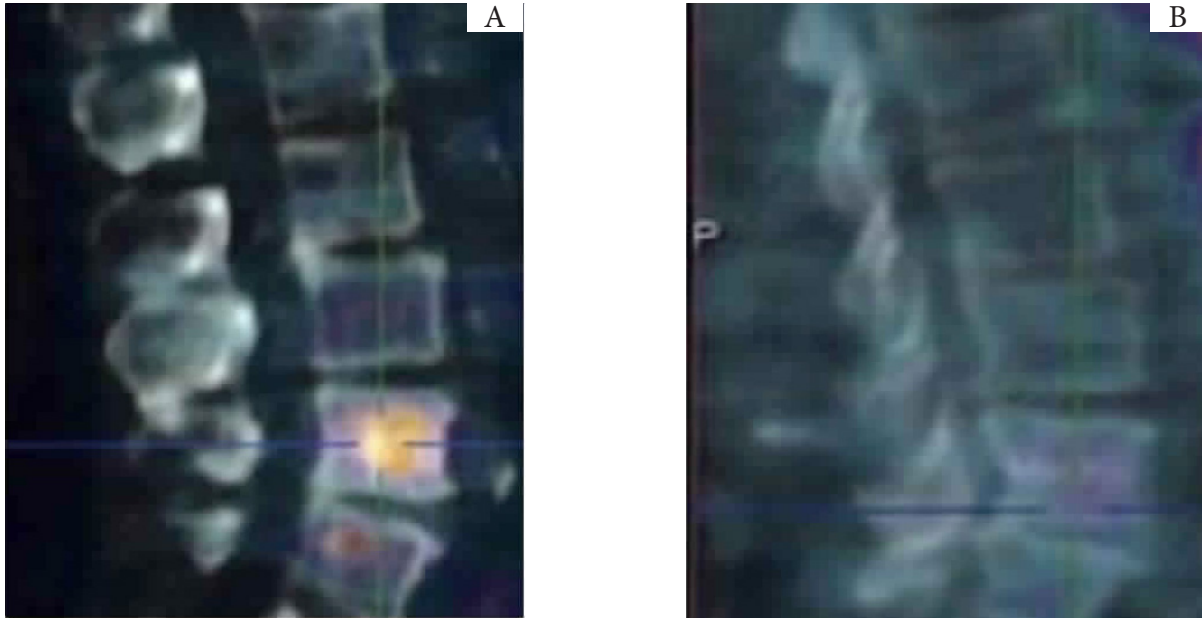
^{18}F -Choline-PET/CT at lumbar spine level; (A) before radiotherapy and (B) after radiotherapy
